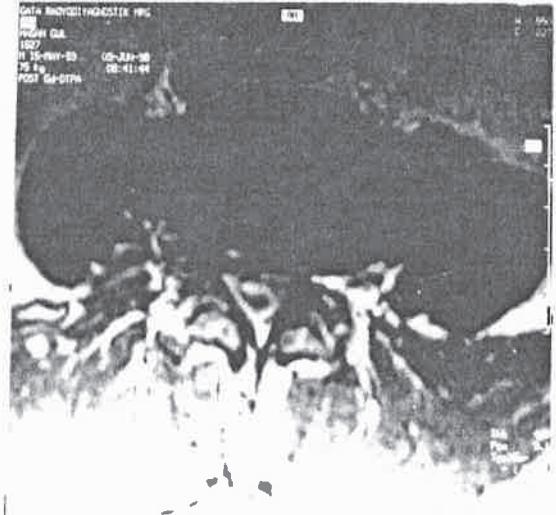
The posterior epidural disc fragment is hiperintense on axial magnetic resonance T1-weighted image with gadolinium enhancement. The disc fragment is posterior and to the right of the thecal sac.
